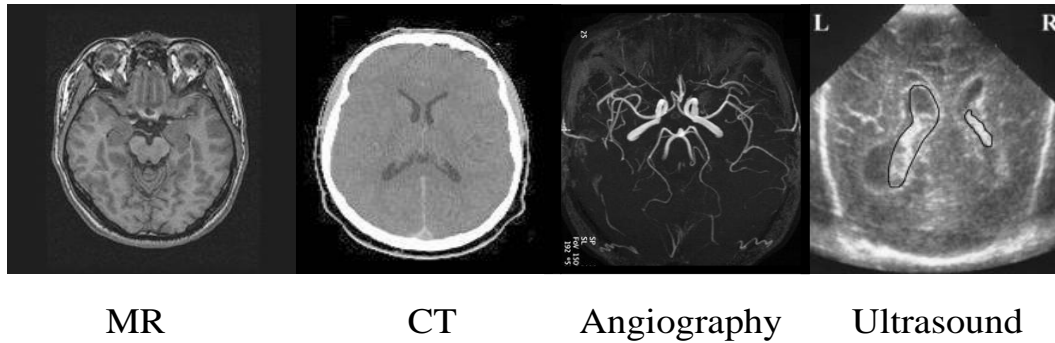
Anatomical Brain Images. MRA is from <http://radi.med.hokudai.ac.jp>. Ultrasound is from <http://www.medphys.ucl.ac.uk>.
